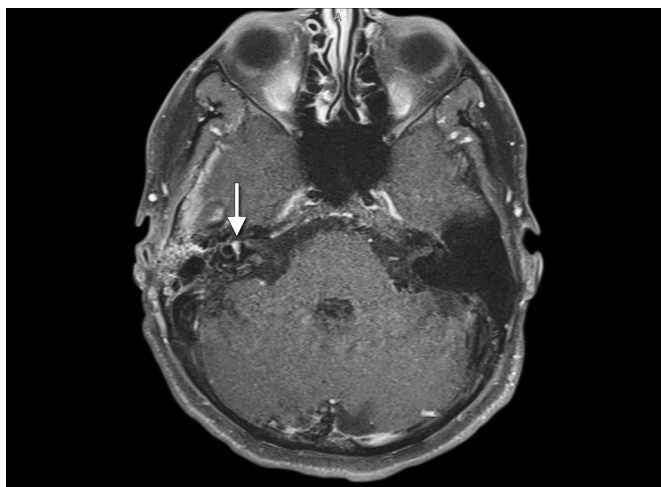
Labyrinthitis MRI. T1-weighted MRI postgadolinium axial view in this patient after mastoidectomy for ongoing otitis media and right-sided acute mastoiditis with symptoms of profound hearing loss reveals enhancement in the right vestibule (white arrow) and labyrinth as seen in comparison to the nonenhancing contralateral side.
